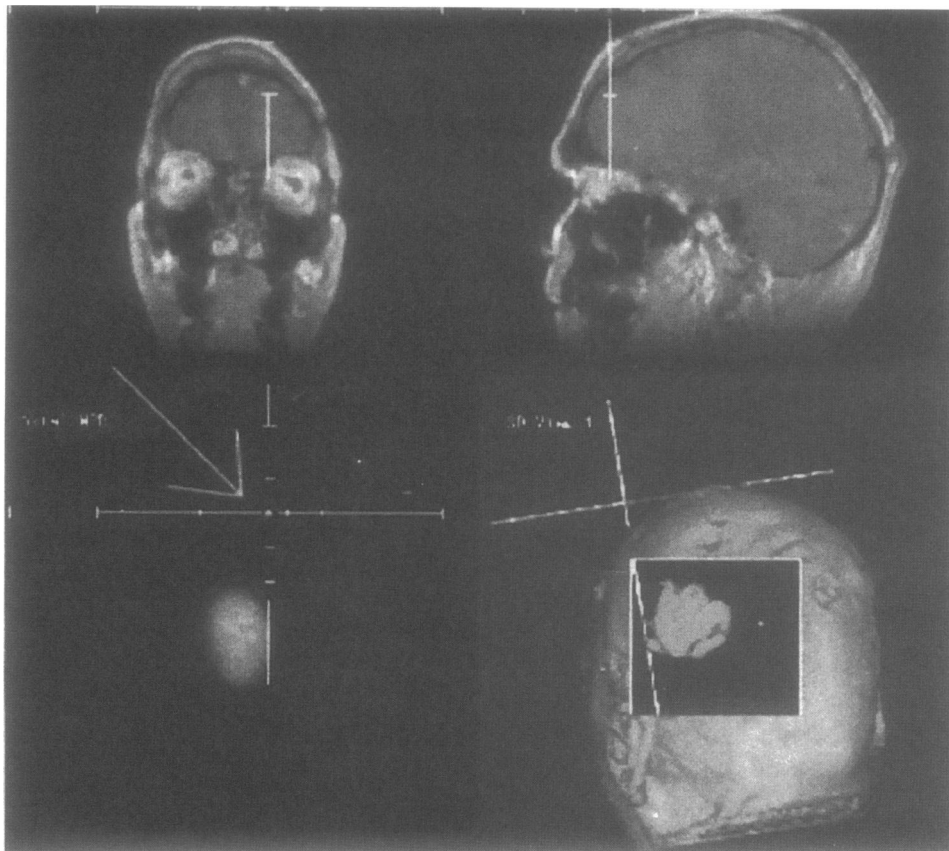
Software "screen shot" from ISG Viewing Wand™ computer monitor showing a three-dimensional and three planar views of MRI-acquired and reformatted images from a patient in the study. The cross-hairs are centered on a bone fiducial point for registration (arrow).
